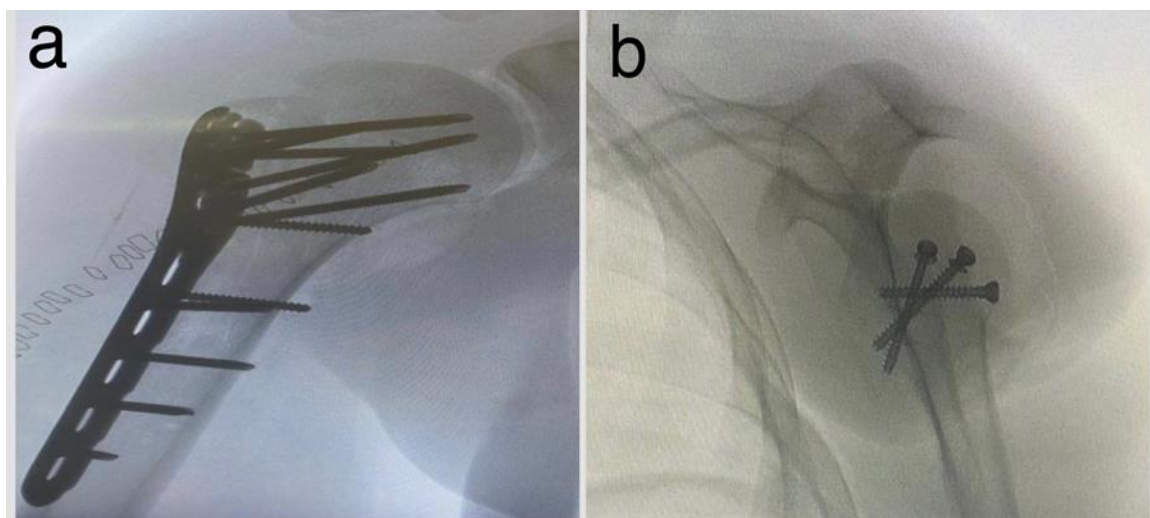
Post-operative X-ray radiographs of the (a) right shoulder and (b) left shoulder.
